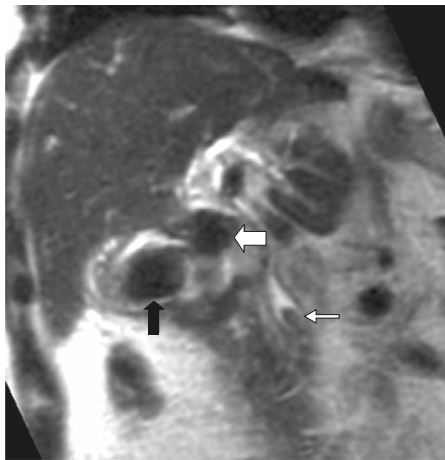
Oblique coronal T2-weighted magnetic resonance imaging (TR: 1,393 ms; TE: 92 ms) revealed a laterally displaced gallstone (black arrow) caused by the pseudoaneurysm (thick white arrow). A low-signal-intensity material suggestive of blood clot or hemorrhage was also noted within the gallbladder and the common bile duct (thin white arrow).
